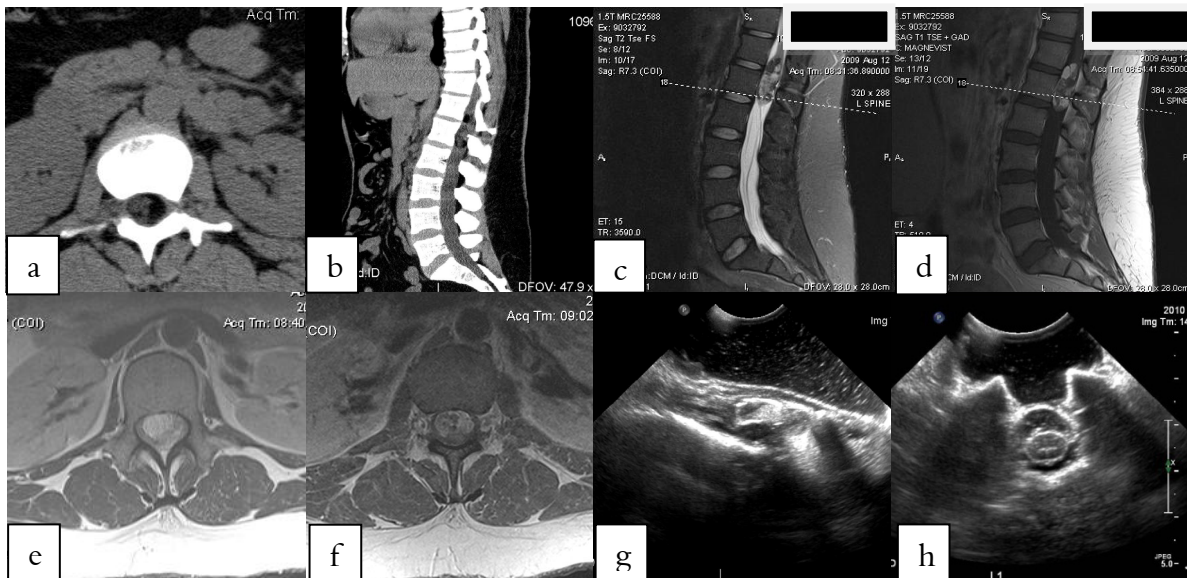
Dermoid cyst T12-L1 – axial CT(a), sagittal CT(b), sagittal T2(c), sagittal T1-Gd(d), axial T1(e,f), intraoperative ultrasonography (g,h) - inhomogeneous aspect, calcifications present. (Thanks to Dr. Michael Fehlings – University of Toronto, for allowing us to present the case)
